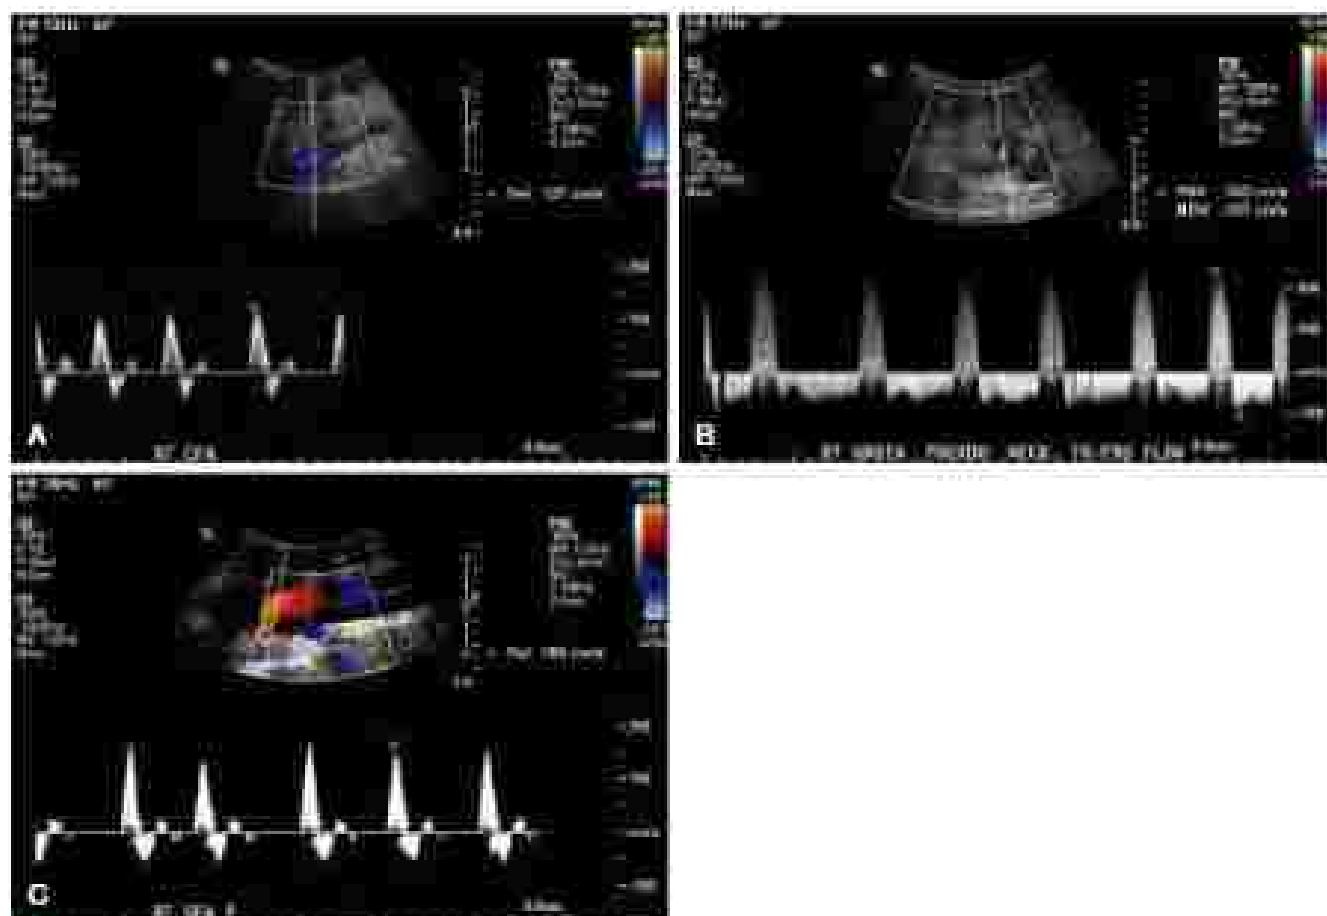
Duplex ultrasound examination of a 3.0 cm pseudoaneurysm at well as the (A) proximal and (C) distal views. Duplex ultrasound shows a patent common femoral artery and superficial femoral artery. The pseudoaneurysm arises from the common femoral artery with chaotic post-systolic retrograde and to-and-fro flow representing systolic flow entering the common femoral artery and retrograde diastolic flow exiting the pseudoaneurysm.
